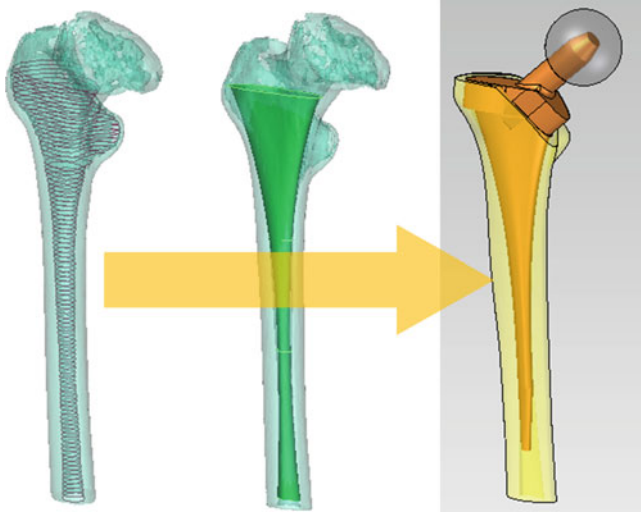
Example of personalized prosthesis designed from the information of CT images. Mimics combined with solid edge as software support tools
